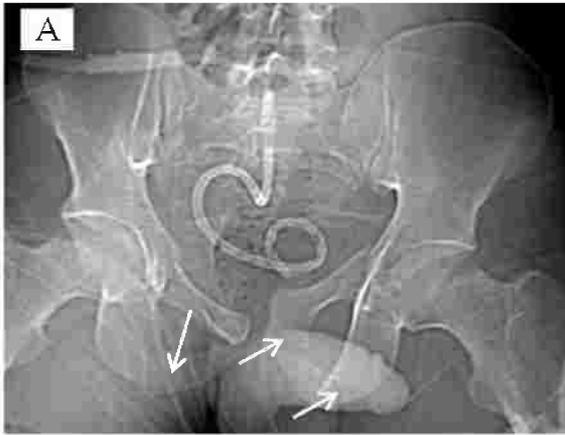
16 years old male with history of Falling from height, (A) plain x ray anteriorposterior view, (B, C, D) axial, (E) coronal CT bone windows and (F,G,H) VR images they are showing left iliac wing bone fracture reach the SI joint (long arrows in B,F,G,H) with diastasis anterior of the left SI joint, and sacral fracture (arrow head in B,E,F). Fragment is noted in B and E (Green arrow). There is fracture in both right and left inferior pubic rami (short arrows in C,D,F,G,H).
